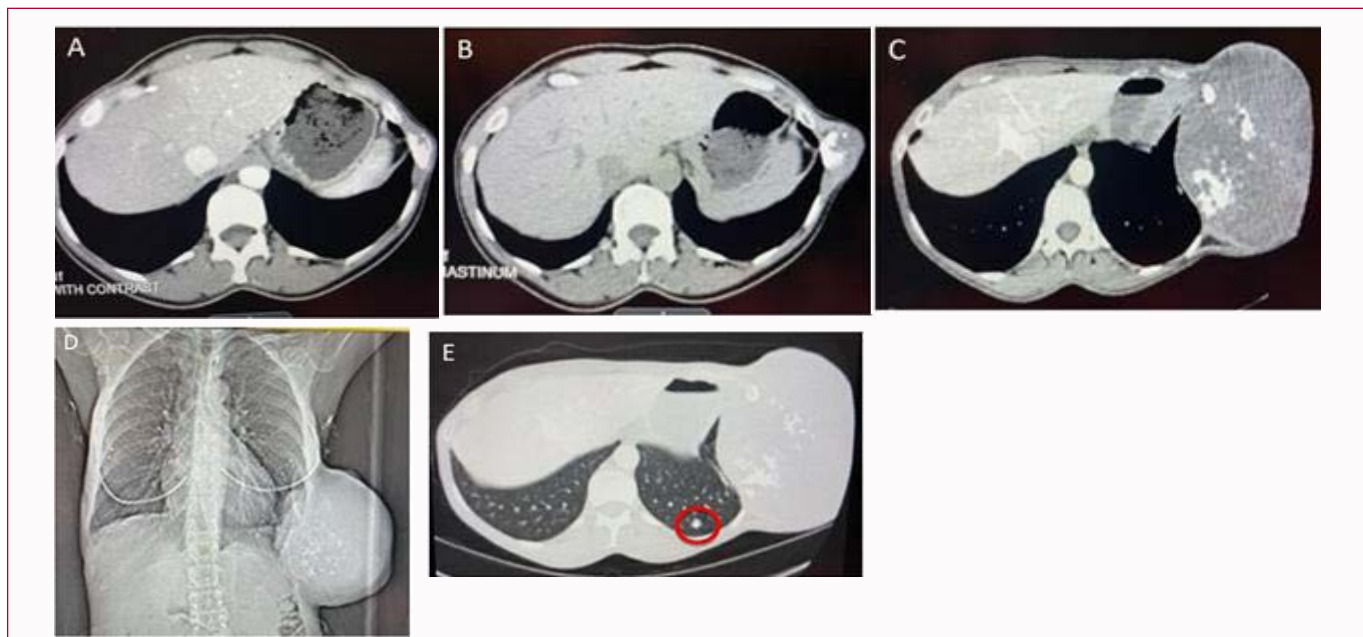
CT scans of enlarging chest wall mass. (A-D) CT scans of chest over 10 years showing enlargement of the left lower chest wall mass arising from the 9th rib initially. (E) Development of an indeterminate pulmonary nodule (red circle) within the left lower lobe.
